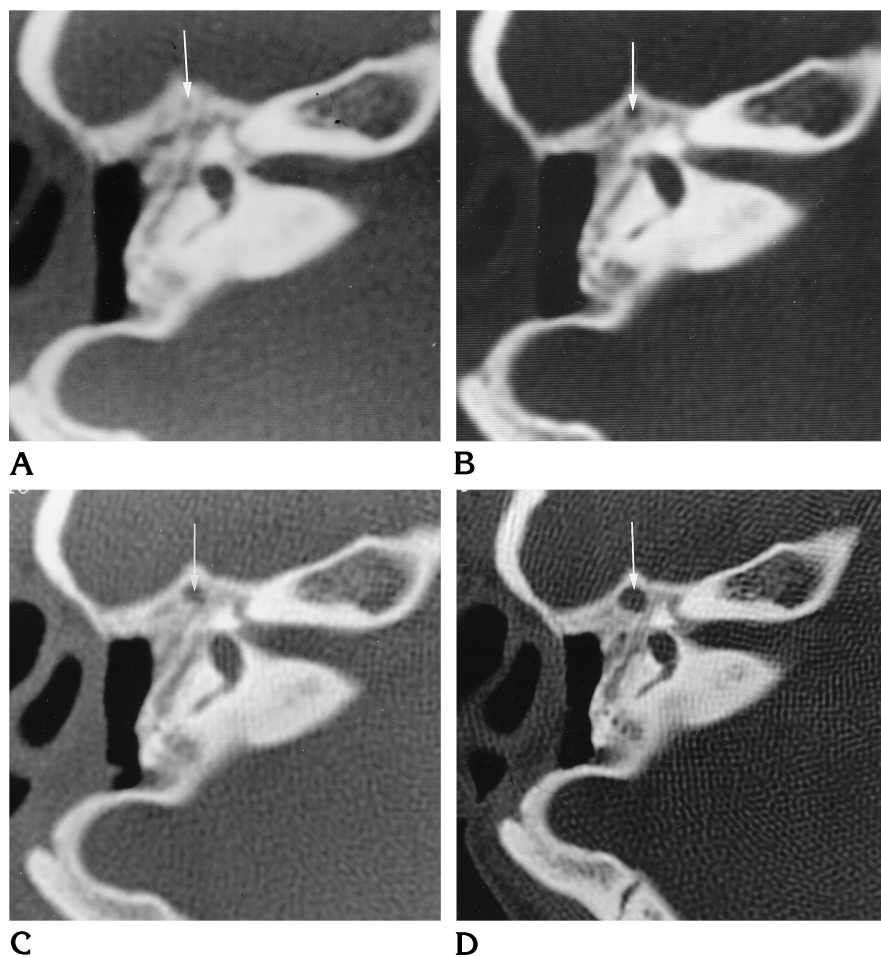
Recurrent cholesteatoma. High-resolution CT scans obtained over a 4-year period show progressive, smooth enlargement of the anterior epitympanic recess (*arrow*) in a patient with a prior radical mastoidectomy. *A*, One year after mastoidectomy; *B*, 2 years after mastoidectomy; *C*, 3 years after mastoidectomy; *D*, 4 years after mastoidectomy. Any of the images if viewed in isolation might suggest a fluid-filled anterior epitympanic recess rather than a mass lesion.
